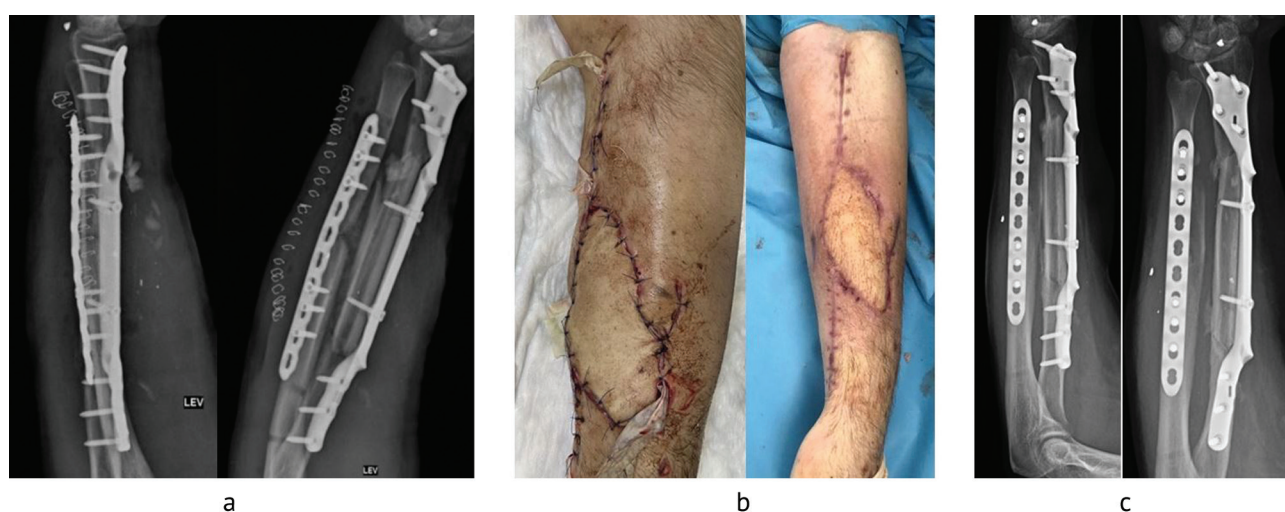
Patient M.: *a* radiographs after the intervention; *b* views after the operation and after suture removal; *c* radiographs 6 months after the operation
